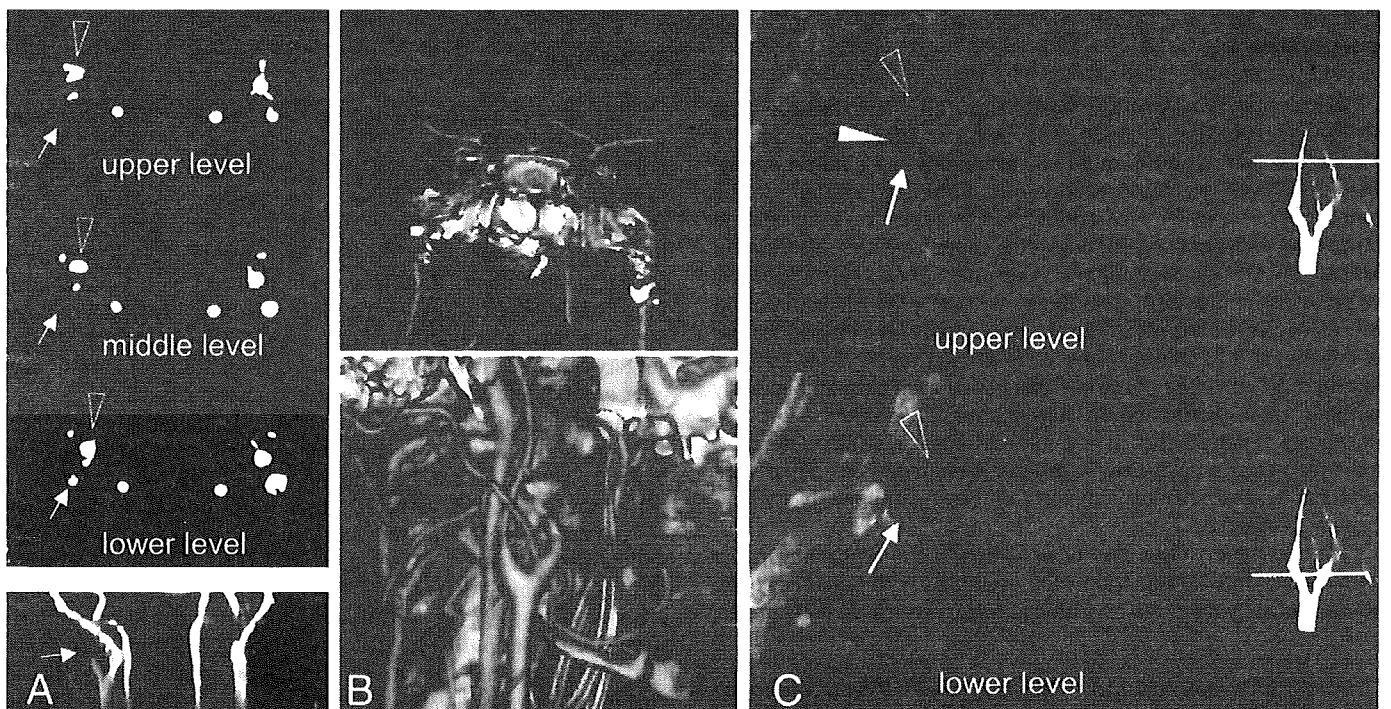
MRI and 3D-CT angiography during the second stroke event. Cervical 3D-TOF MRA on admission of the second stroke shows right ICA occlusion distal to the carotid bifurcation (A). Source image did not show intramural hematoma or intimal flap. However, 3D-CT angiography on day 7 showed reopening of the right MCA and ICA (B). The right ICA appears smooth and thin vessel without calcification. Black-blood MRI obtained on day 21 reveals neither intramural hematoma nor atherosclerotic plaque in the right ICA (C) (ICA, external carotid artery, and occipital artery are indicated by arrow, open arrowhead, and solid arrowhead, respectively).
